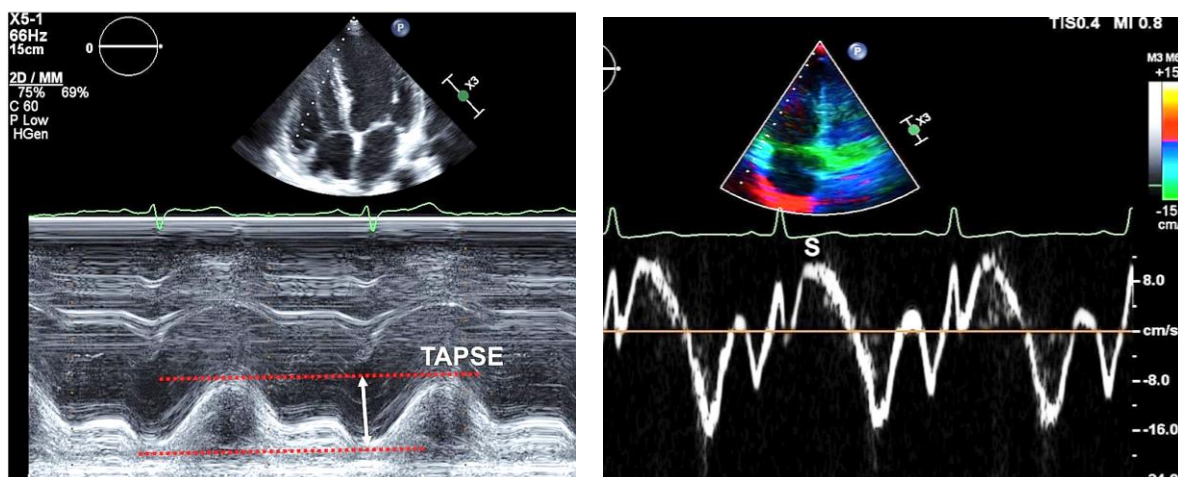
Assessment of tricuspid annular systolic excursion (TAPSE) by M-mode (Left), and measurement of right ventricular peak systolic velocity (RVS) using pulsed Doppler tissue imaging.
